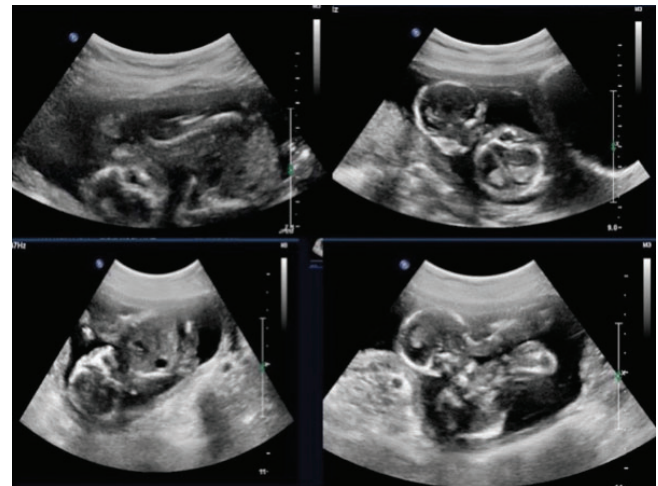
Antenatal ultrasound showing thoraco-omphalopagus conjoint twins .Note fused upper chest to the lower chest and abdomen ,2 separate heads and spines and single heart and liver.
